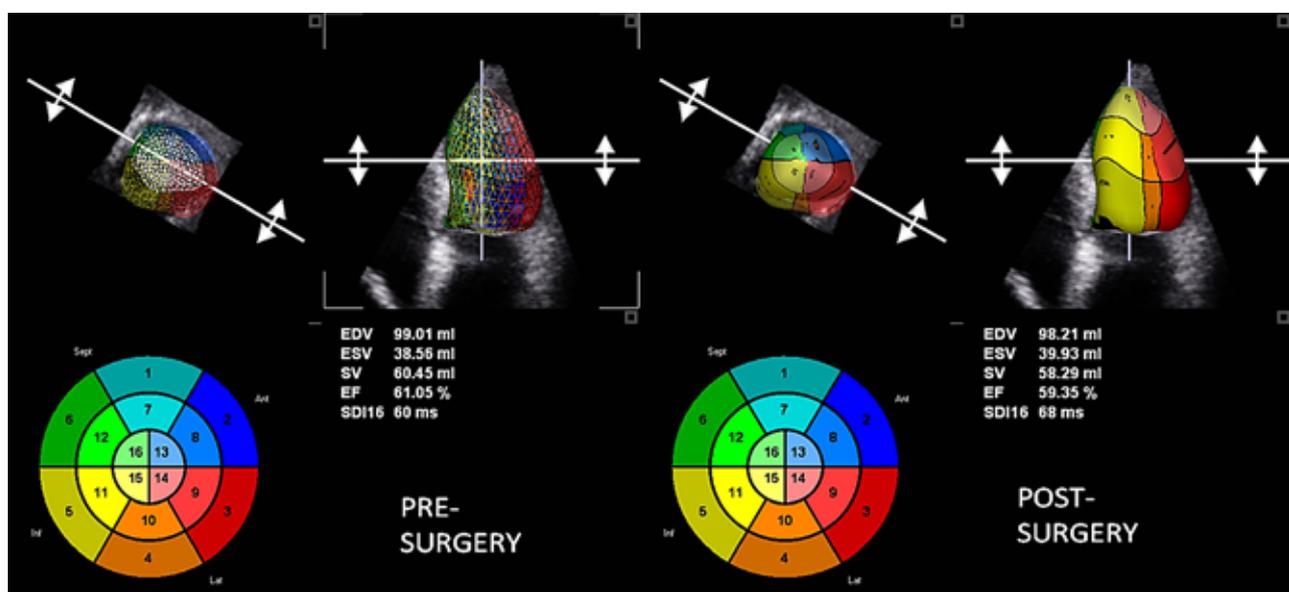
Real time three-dimensional echocardiography immediately pre- and 8 weeks post modified Cabrol.
